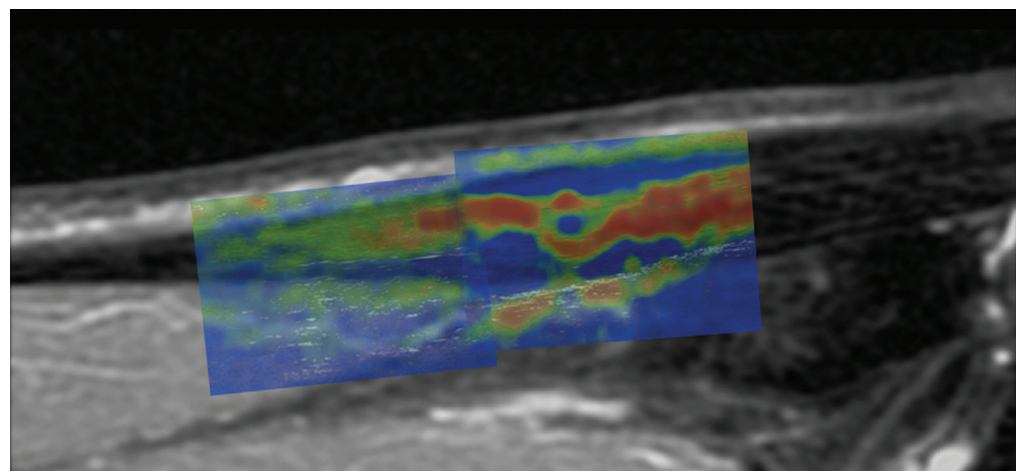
Fusion of the MRI image and elastography demonstrate that both techniques identify a similar area of tendinitis.
